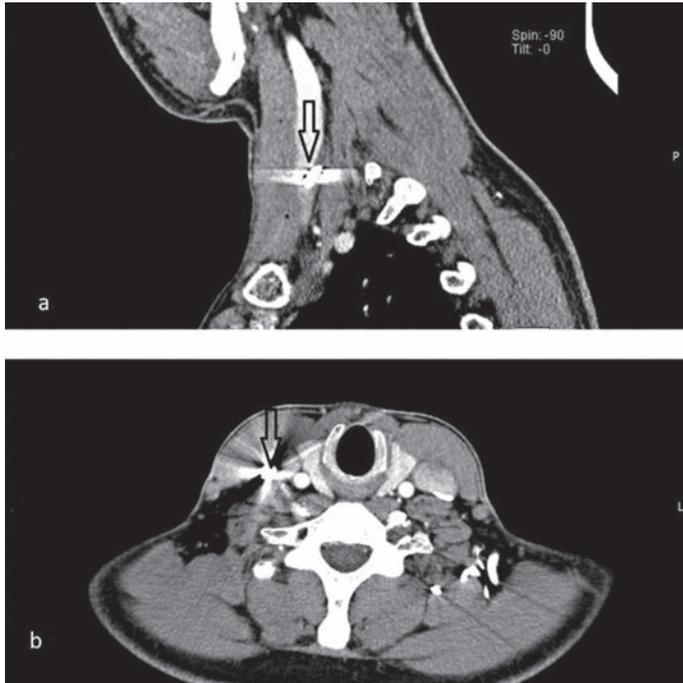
View of the foreign body in the neck: a- Foreign body in the right internal jugular vein on sagittal CT angiography (black arrow); b- Radial image of the metallic foreign body on axial CT angiography of the neck (black arrow).
